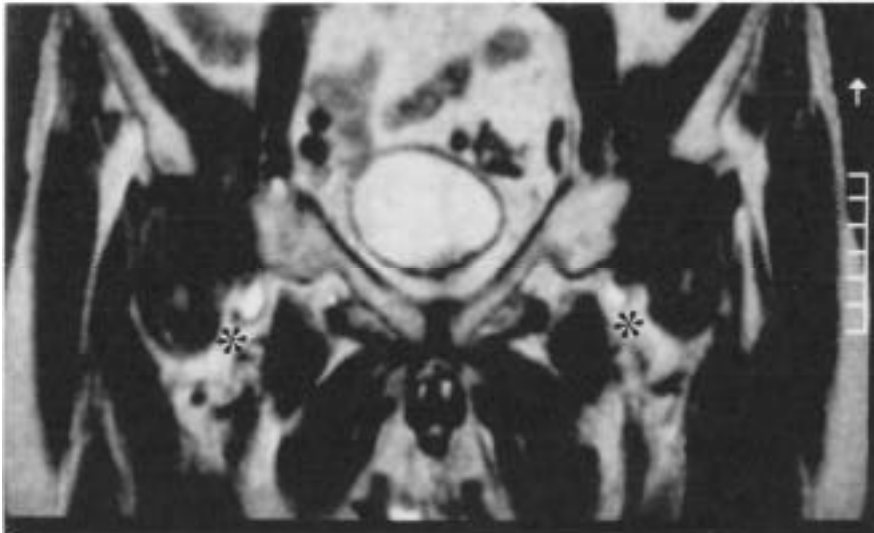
Axial T2-weighted MRI scan of the hip in PMR: presence of fluid within the iliopsoas bursae (asterisks) suggesting bilateral bursitis.
